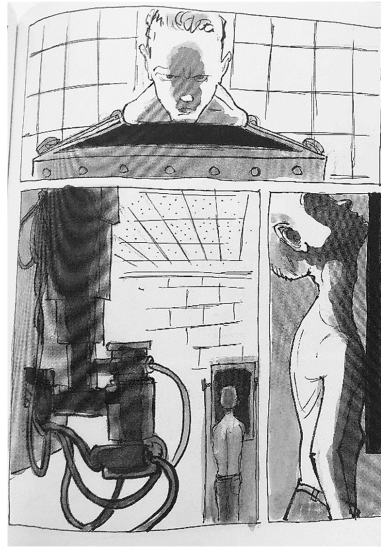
David receives x-ray shots to examine his growth (Small 131).
